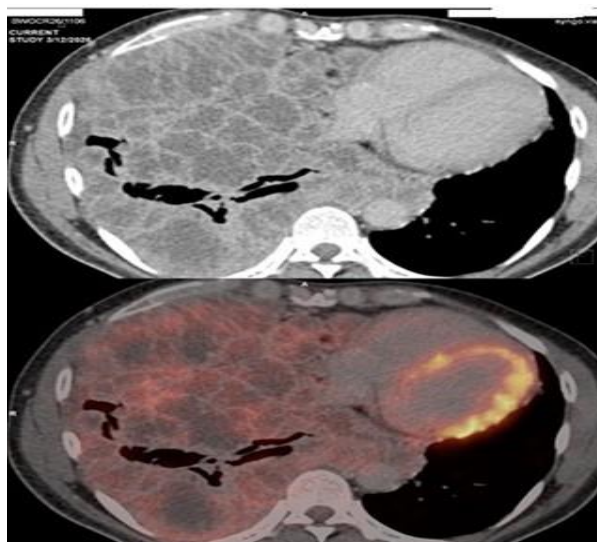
Axial CECT (upper) and fused PET-CT (lower) — inferior pleural mass with heterogeneous metabolic activity and extraneous posterior mediastinal impingement.
